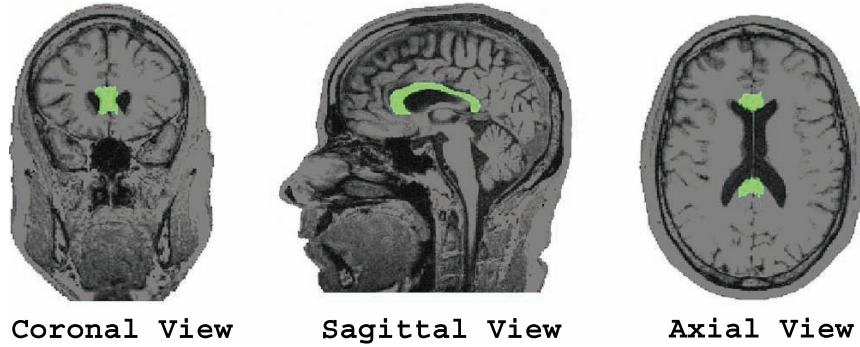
Manually segmented callosal structure overlaid on an MRI image.
